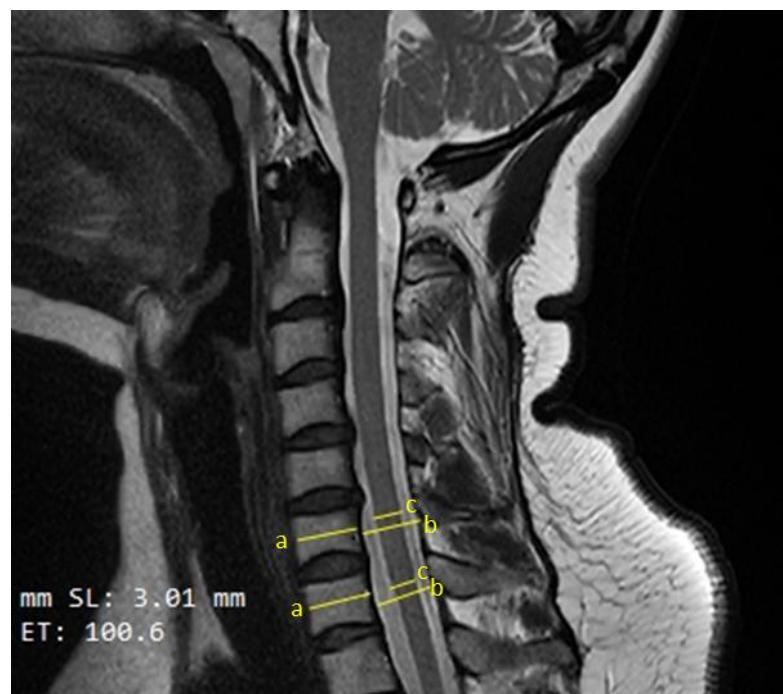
Mid-sagittal T2 weighted MRI image of cervical spine in a 59 year female patient. Sagittal-diameter measurements of the spinal cord, spinal canal, and vertebral body.
